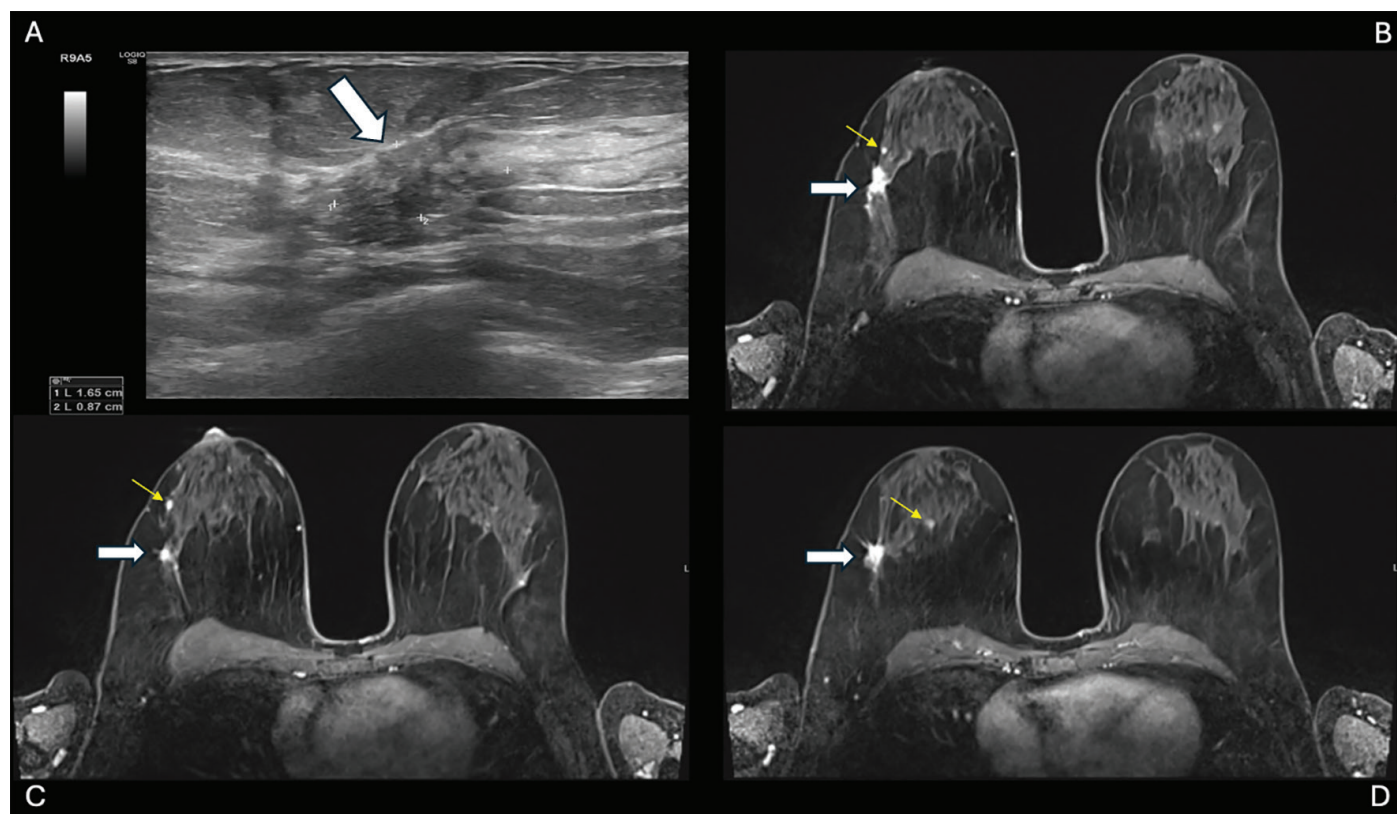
Multifocal invasive ductal carcinoma in a dense breast detected only on MRI. A 51-year-old woman presented with a palpable mass in the right breast. Ultrasound (A) showed a single irregular hypoechoic lesion (bold arrow) at the 9 o'clock position, 5 cm from the nipple, measuring 17×10-mm, with no additional suspicious findings. Breast MRI, performed due to dense parenchyma, confirmed the index circa 20-mm (B) mass (bold arrow) in the mid-outer quadrant and revealed three additional enhancing foci (thin arrows): two up to 5-mm (C) located 2 cm anterior to the index lesion and a 7-mm (D) focus anteromedially, consistent with multifocal disease. Tru-cut biopsy of the index lesion showed invasive ductal carcinoma, and the patient underwent nipple-sparing mastectomy with sentinel lymph node biopsy; final pathology demonstrated two invasive foci measuring 32-mm and 8-mm with approximately 10% surrounding ductal carcinoma *in situ*
